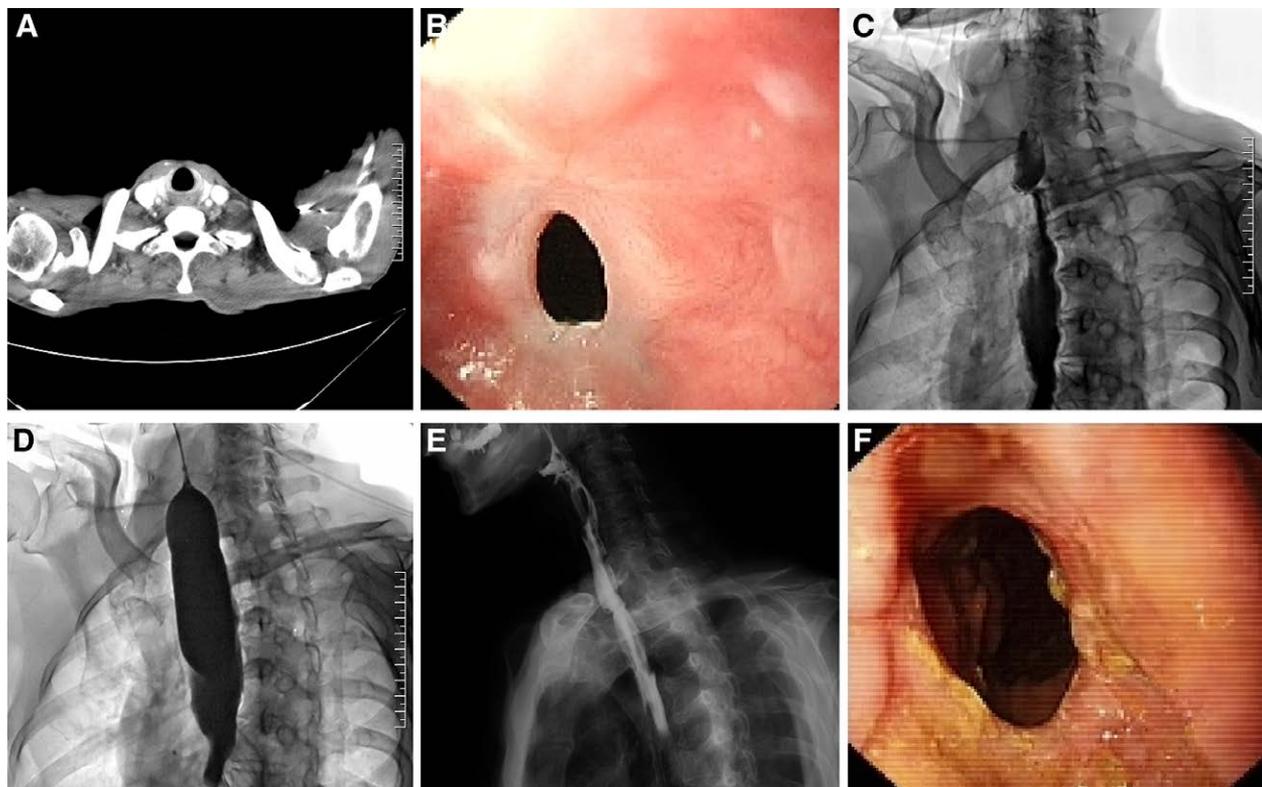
Seventy-two year-old male with esophageal anastomotic stricture secondary to esophageal resection. (A) CT showed anastomosis with no tumor recurrence. (B) Fibergastroscopy showed a 5mm diameter anastomotic stricture 2.6 months after operation. (C) Esophagography show severe anastomotic stricture in the level of sternoclavicular joint. (D) The large balloon was fully dilated by a 30mm diameter balloon catheter. (E) No stricture or leakage was observed after dilatation after water soluble contrast esophagogram. (F) Fibergastroscopy showed anastomotic stricture disappeared after dilatation. CT = computerized tomography.
